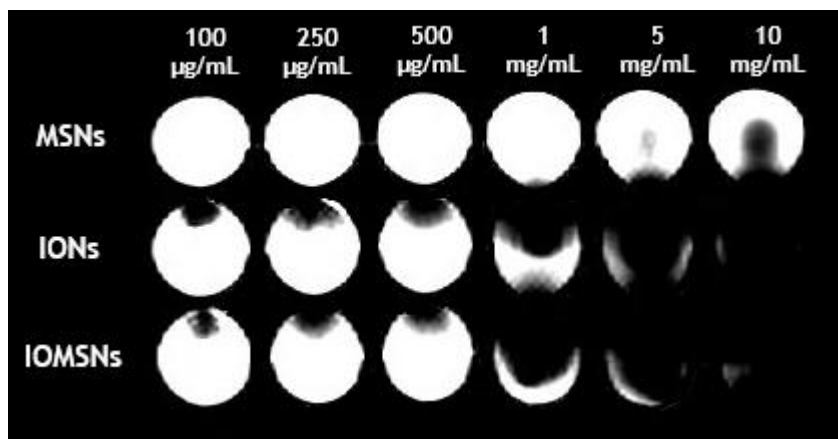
Magnetic Resonance Imaging of MSNs, IONs and IOMSNs, T2-weighted image.
